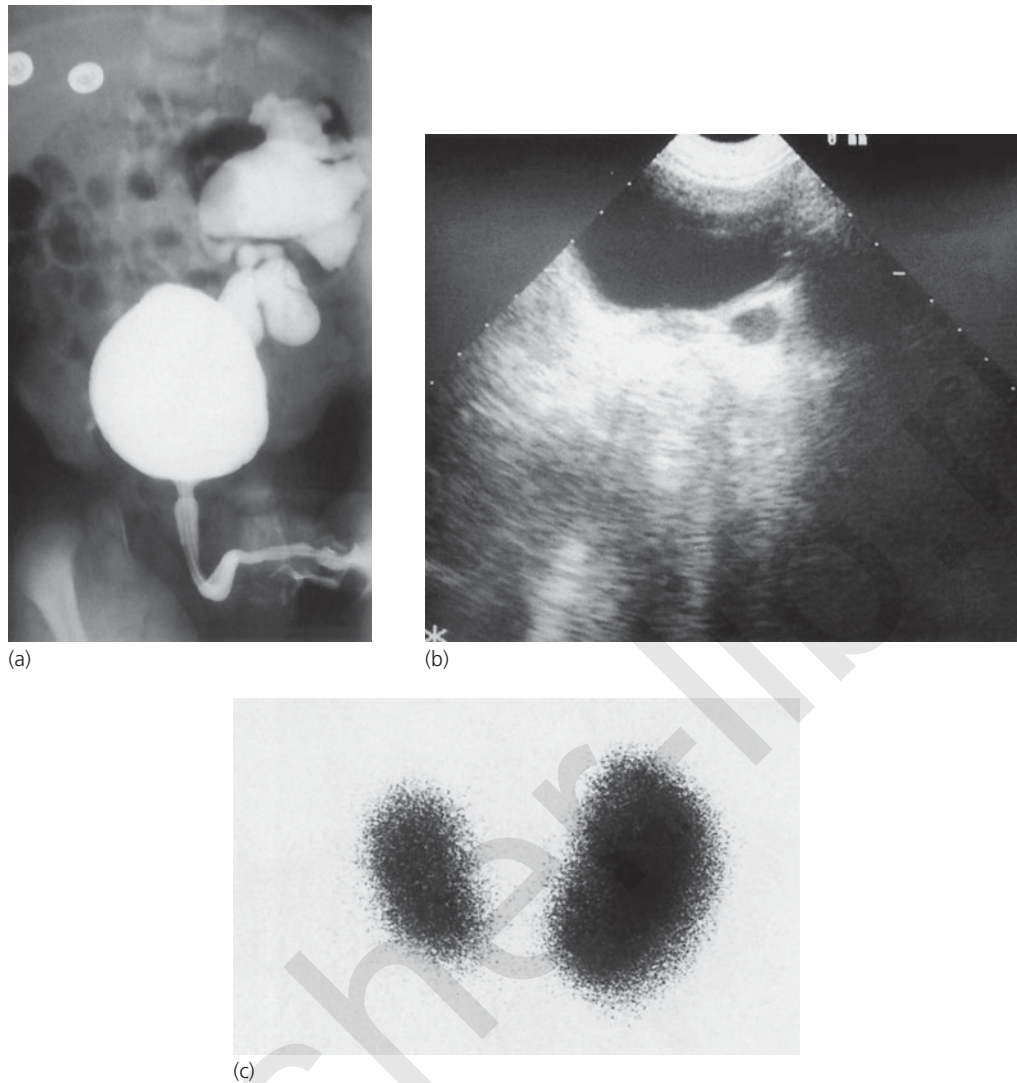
(a) Male infant showing grade V left vesico-ureteric reflux; (b) ultrasound in the same patient. Transverse scan through the full bladder demonstrates dilated left ureter. (c) DMSA scan in the same patient demonstrates small left kidney.
